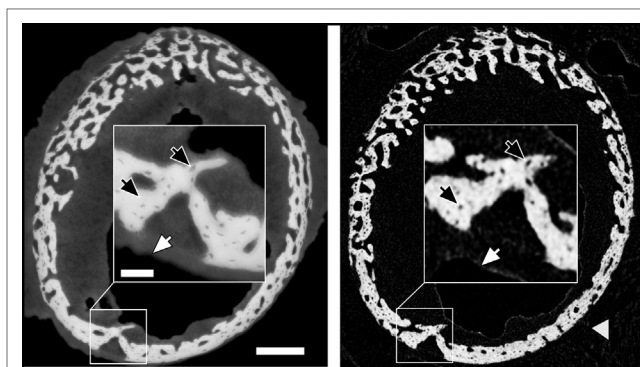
Comparison of similar cross-sections in a 10-day sample imaged by holotomography (left) and a laboratory source CT (right). The gray arrow head highlights gauze, which supports the bone during the lab CT scan. The scale bar equals to 200 μm . The inset shows a high magnification (scale bar = 50 μm) to highlight the differences in feature visibility between the methods. Dark arrows pinpoint osteocyte lacunae, and white arrows hint to the transition between soft tissue and air.
